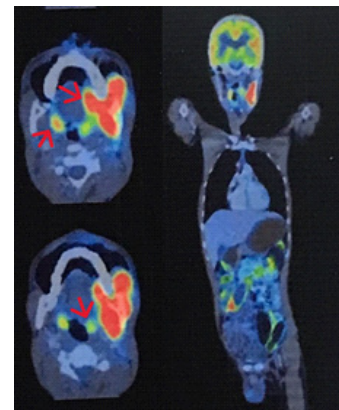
PET CT shows a large lobulated heterogeneously enhancing metabolically active soft tissue mass lesion with irregular margin in the left retromolar trigone and masticator space involving ramus with evidence of cortical erosion representing primary malignant lesion. A few prominent mildly metabolically active left upper cervical nodes
